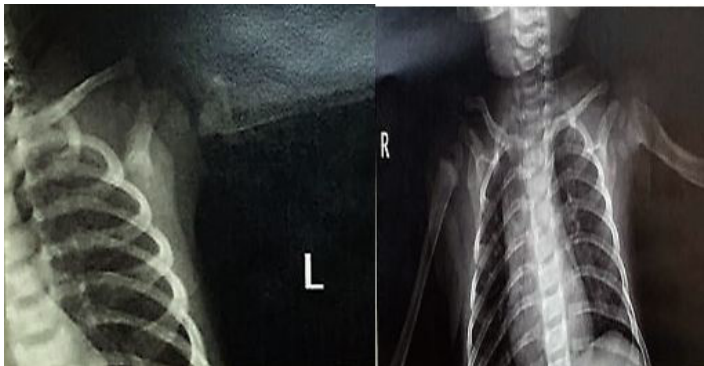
1-month control radiographs. Figure 4: 3 months control radiographs
